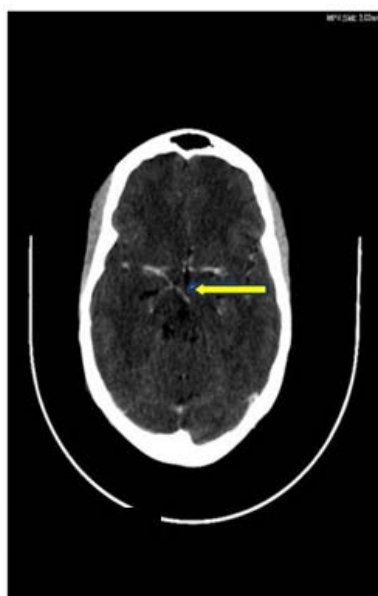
Contrasted CT image. Showing 'beading' of the paramedian blood vessels supplying the midbrain (signs of vasculitis)
